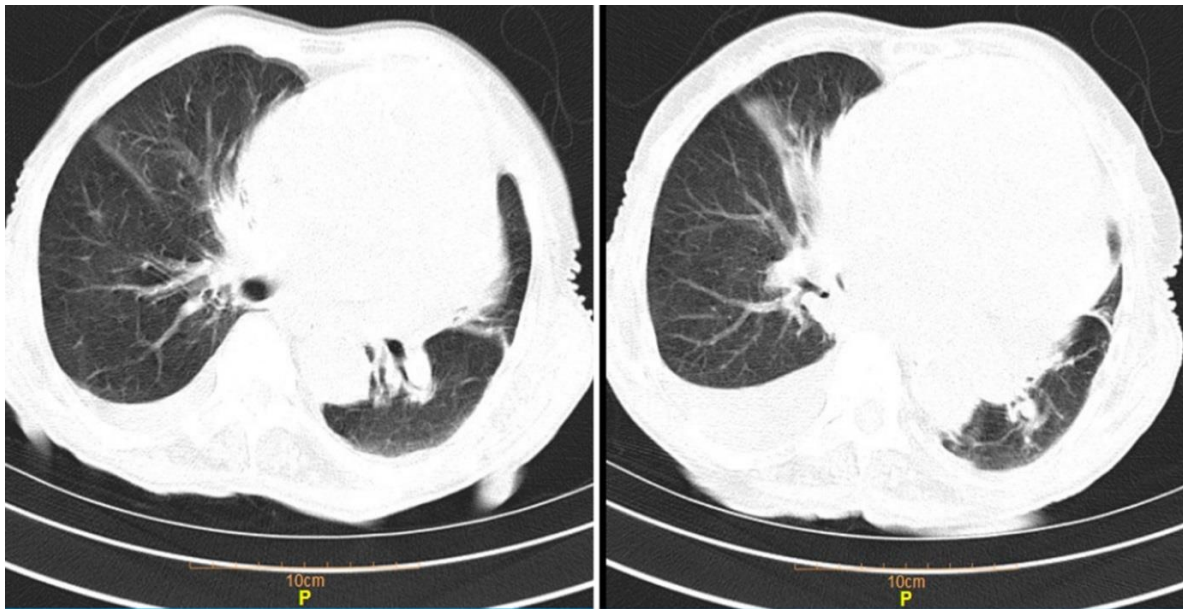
Pulmonary computed tomography angiography shows cardiomegaly without significant pulmonary artery stenosis.
